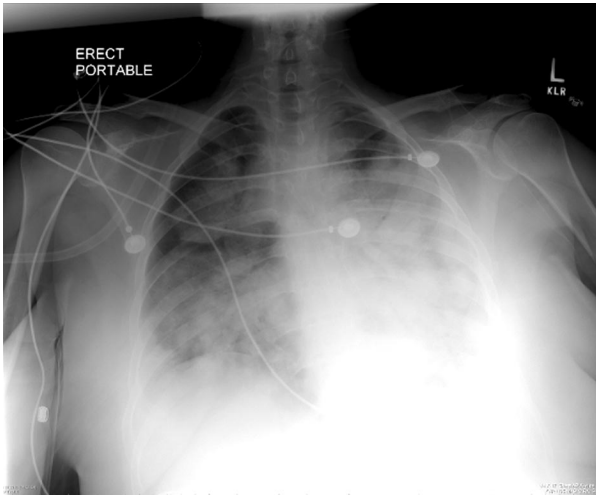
Chest radiograph revealing extensive bilateral pulmonary infiltrates in a patient with H1N1 influenza pneumonia.
